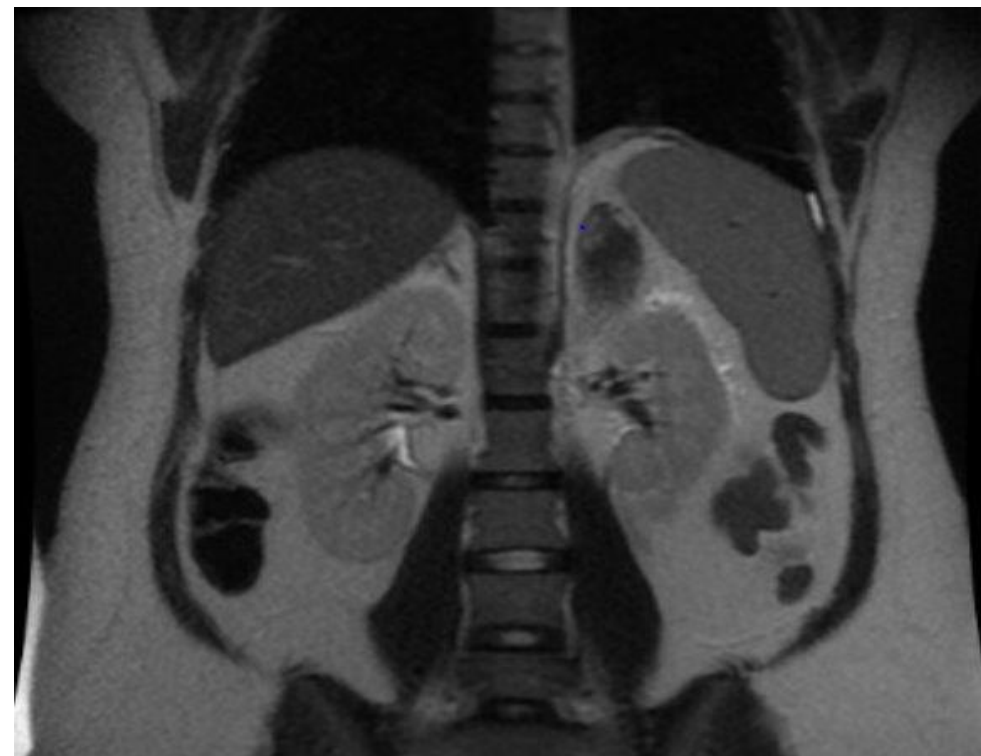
MRI of left adrenal mass measuring 3.5 cm with imaging features favored to represent subacute adrenal hemorrhage
